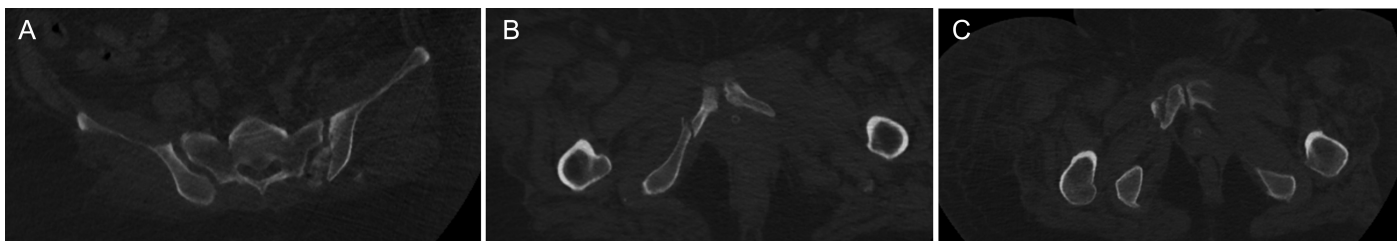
Image of a 61-year-old woman. Axial CT shows crescent fracture of the pelvis (A), the fractures of the right inferior pubic ramus (B, C). CT, computed tomography.
